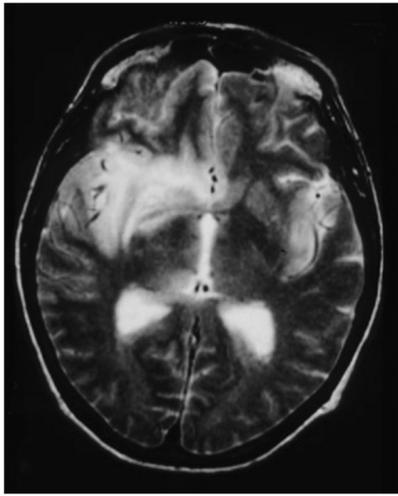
MRI of herpes simplex virus encephalitis with bihemispheric involvement. Greatly increased T2 signal exists in the right hippocampus and orbitofrontal cortex, as well as in the left medial temporal lobe and insula.
